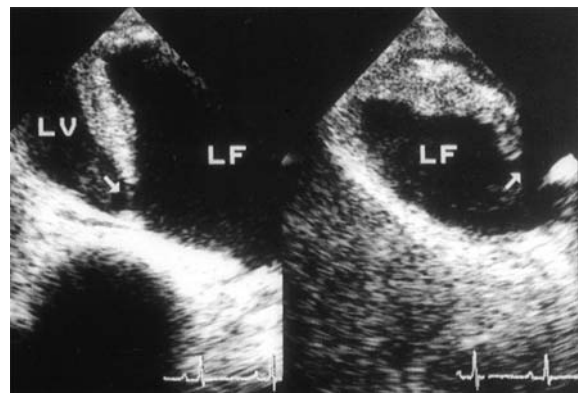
Transesophageal echocardiographic scans of a patient with a limited acute aortic dissection secondary to an aortic ulcer. A thick, calcified, irregular flap can be seen. Longitudinal planes. Arrow entrance tear, LF false lumen, LV true lumen
